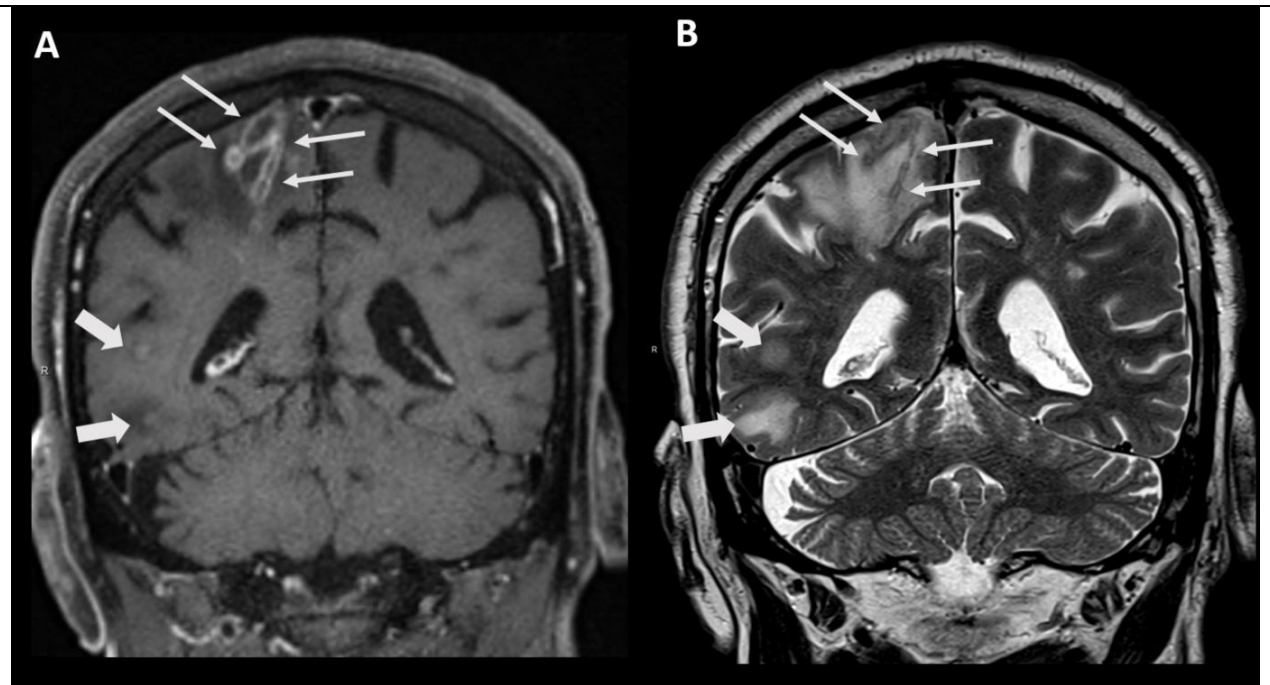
Brain MRI, coronal contrast-enhanced T1-weighted image (A) and coronal T2 TSE image (B). Some of the parietal lesions show a unique tubular (“worm-like”) appearance (thin arrows in A and B). Other infective lesions with faint nodular contrast enhancement in the temporal lobe of the same hemisphere (thick arrows). All the lesions show vasogenic edema in the adjacent white matter.
